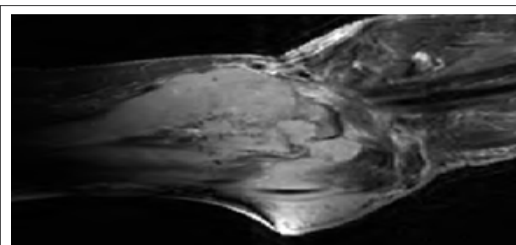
MRI - coronal views of the wrist (T2 weighted).
